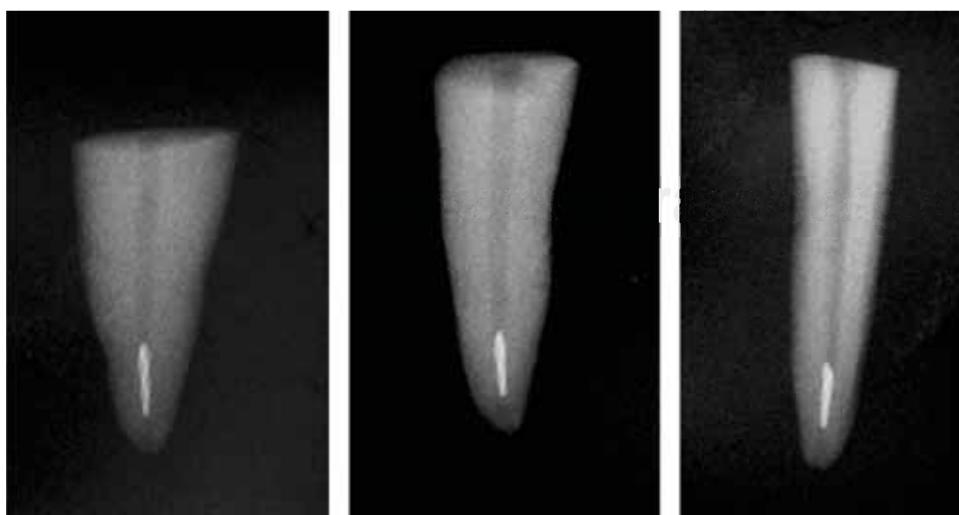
X-ray of apically fractured instrument.
